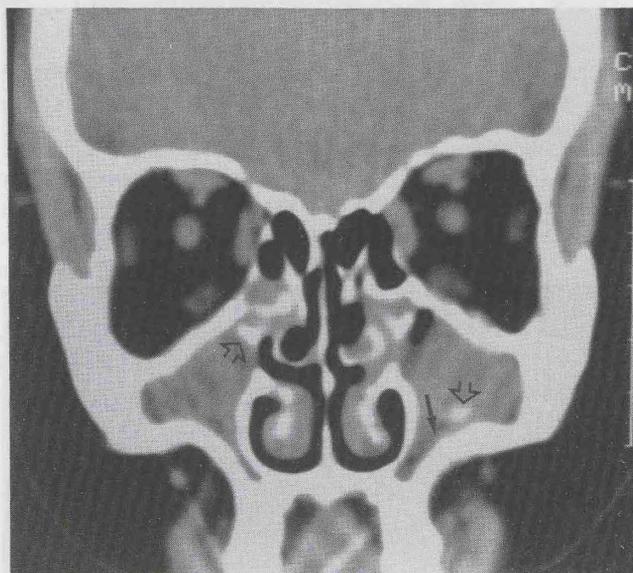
Non-enhanced CT scan: Focal areas of calcification (open arrows) in both maxillary sinus which show sinusitis and reactive osteitis (arrow). Note that the ostiomeatal complex is compromised bilaterally.
